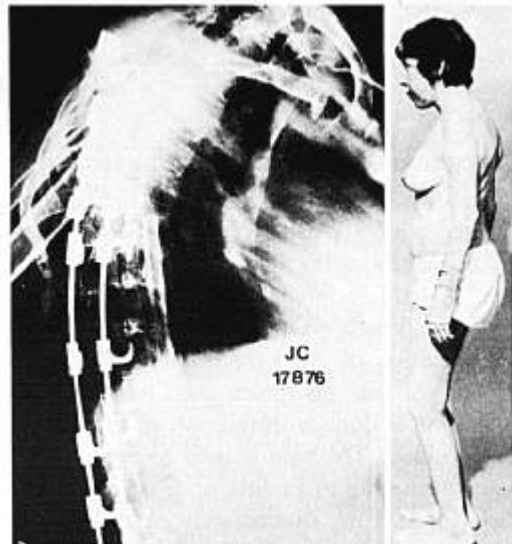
(left) Standing radiography of spine 2½ years postoperatively showing correction of kyphotic deformity. (right) Standing lateral view 2½ years postoperatively showing correction of kyphotic deformity. The patient is 5 inches taller in height.
